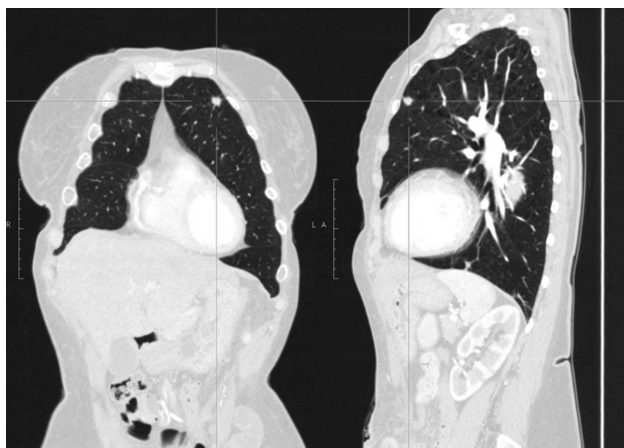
Isolated pulmonary recurrent endometrial disease documented by CT scan.
